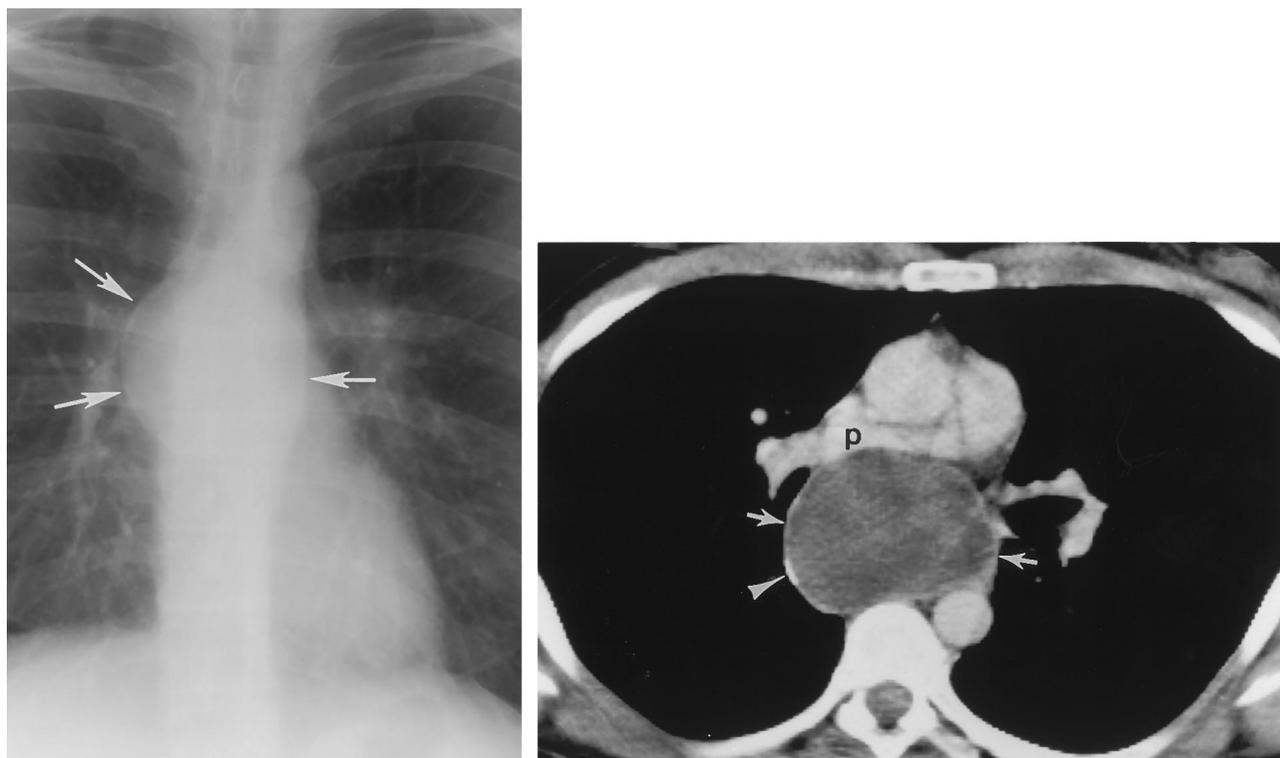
(Left) PA chest radiograph and (right) contrast-enhanced chest CT (mediastinal windows) of a 42-year-old asymptomatic man. A spherical 6-cm subcarinal bronchogenic cyst (white arrows) exhibits homogeneous water attenuation, peripheral curvilinear calcification (arrowhead), and mass effect on the right pulmonary artery (p).
